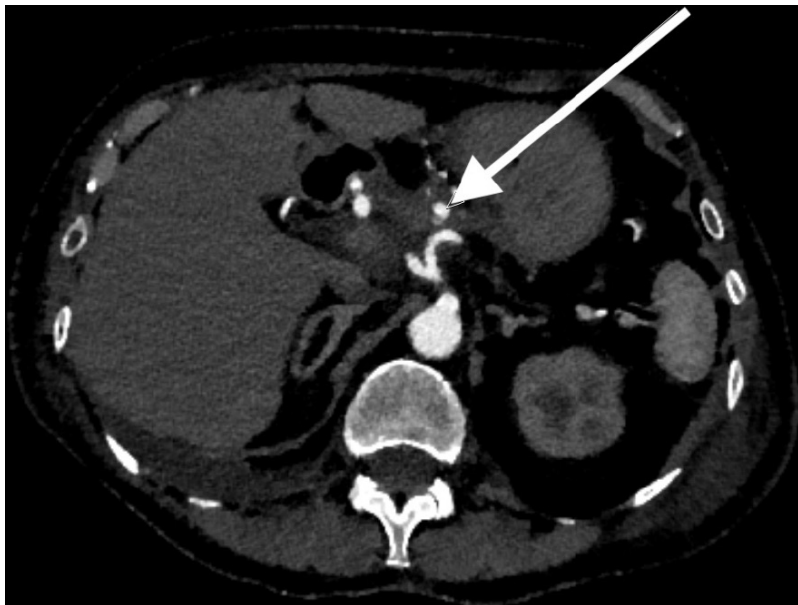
CT Mesenteric Angiogram demonstrating pseudoaneurysm of the left gastric artery
